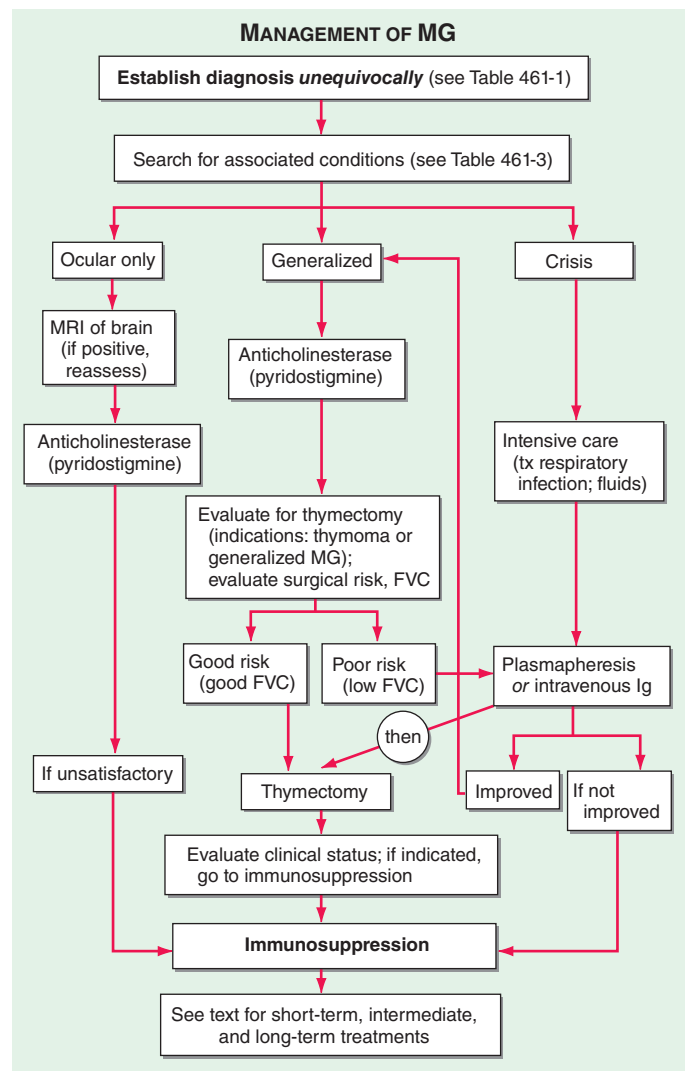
Algorithm for the management of myasthenia gravis. FVC, forced vital capacity; MRI, magnetic resonance imaging.
